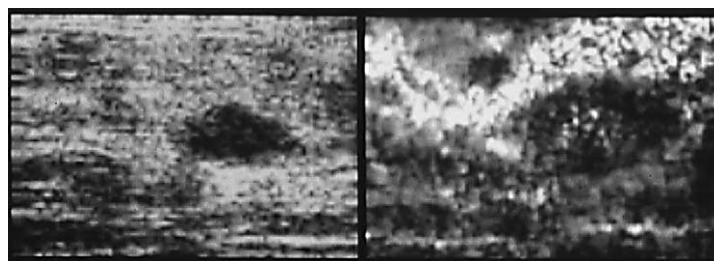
From left to right, matching sonogram and elastogram of breast carcinomas obtained in vivo in the erect position at 5 MHz [23]. Note the demonstration of two hard nodules and the torturous soft subcutaneous fat layer on the elastogram. Note also that the sonogram demonstrates only one hypoechoic nodule and that a size discrepancy exists between the sonographic and elastographic appearance of the large nodule (presumably due to desmoplasia).
